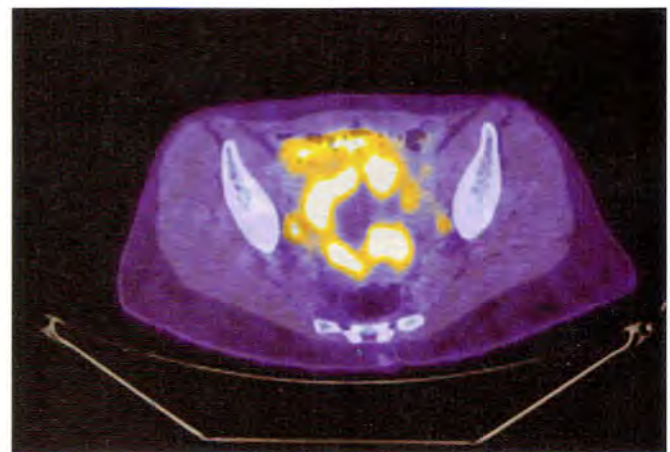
A very large pelvic mass is seen in the anterior portion of the pelvis. It is multiloculated with cold areas of FDG uptake and a SUVmax of 14.1.
